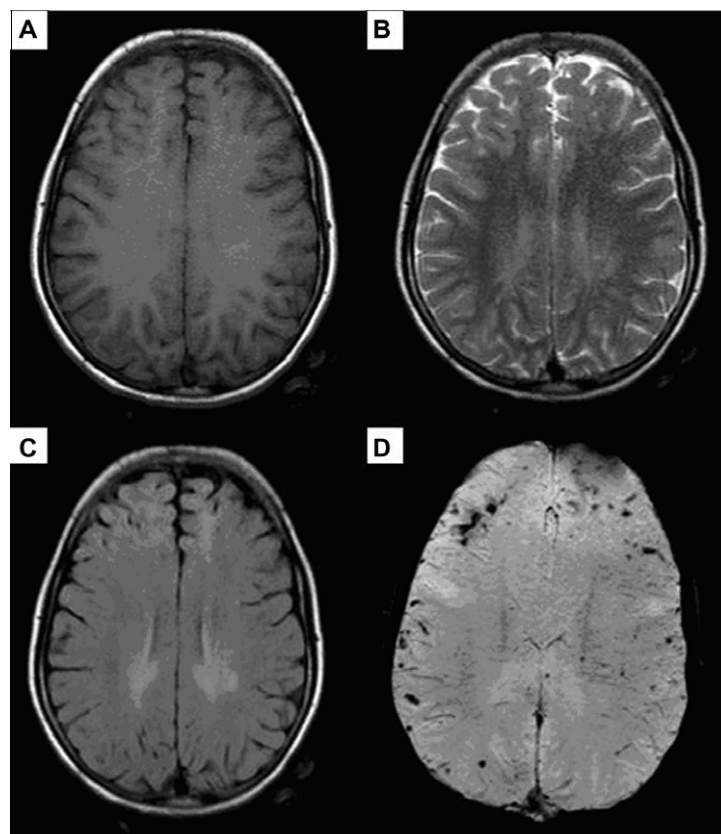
Thirty year old female patient in coma following road traffic accident. Conventional T1 (A), T2 (B) and FLAIR (C) images are unremarkable, while SWI minIP (D) images nicely demonstrate foci of hemorrhage at the gray white matter junctions consistent with diffuse axonal injury.
